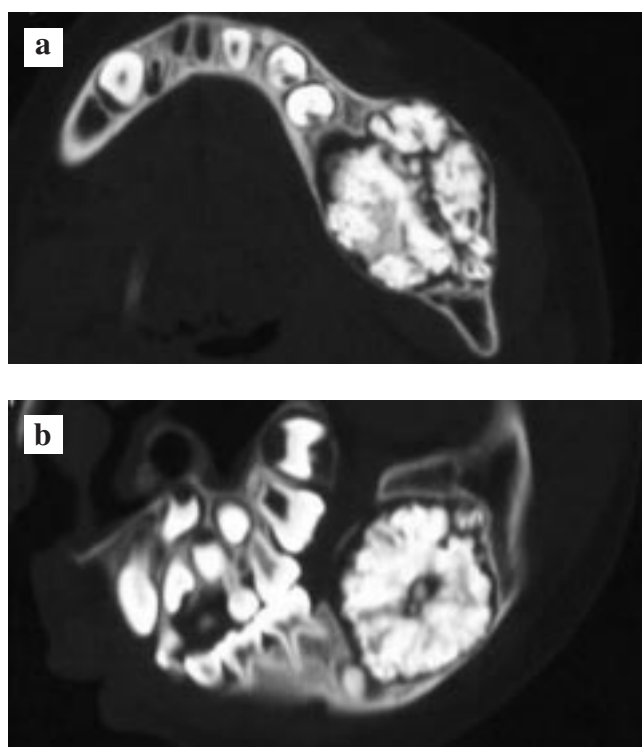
Computed tomography images of the mandible.
